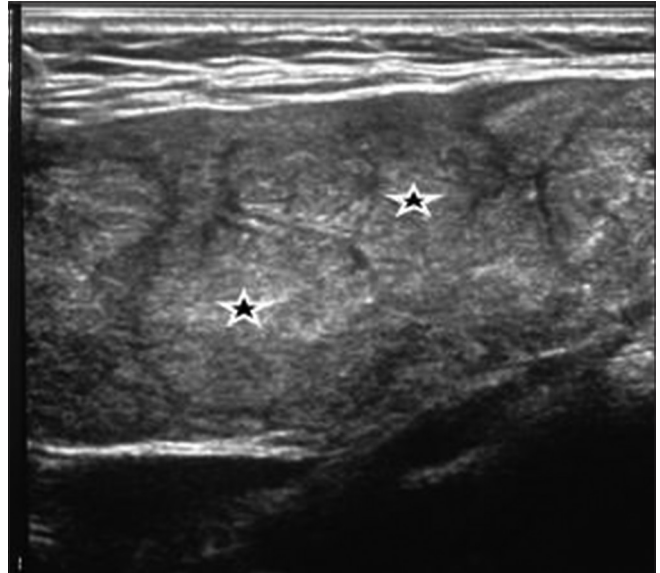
High-resolution sonography image on longitudinal view shows multiple heteroechoic nodules (stars) in submandibular mass lesion whose echo pattern matches that of orthotopic goitrous thyroid gland
